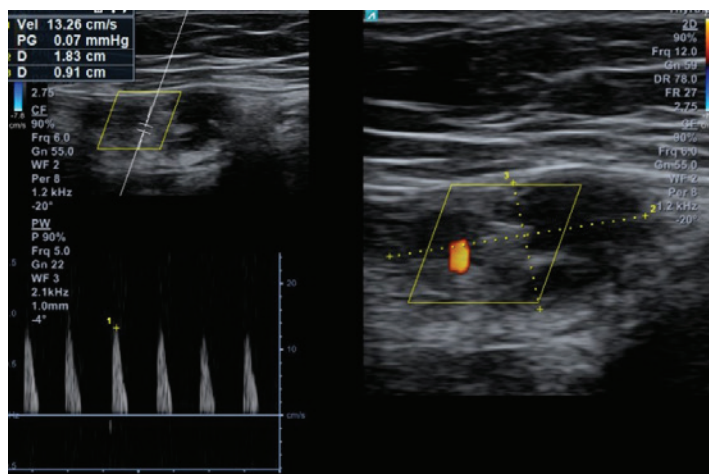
color and spectral Doppler ultrasound in a 33 year old female ,an ill defined border heterogeneous hypoechoic oval shape mass measured 18 x 9 mm invading the muscle with internal vascularity
